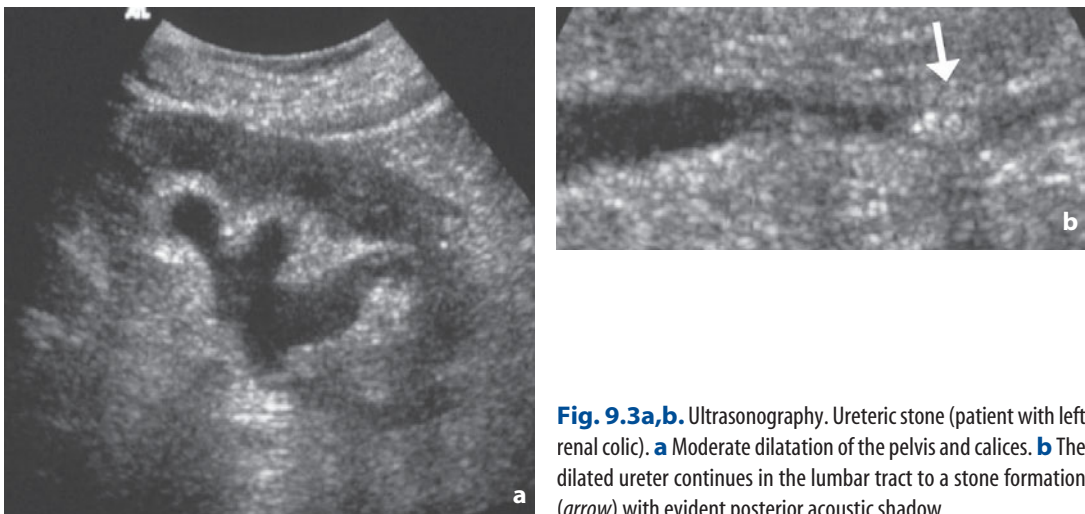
Ultrasonography. Ureteric stone (patient with left renal colic). a Moderate dilatation of the pelvis and calices. b The dilated ureter continues in the lumbar tract to a stone formation (arrow) with evident posterior acoustic shadow
